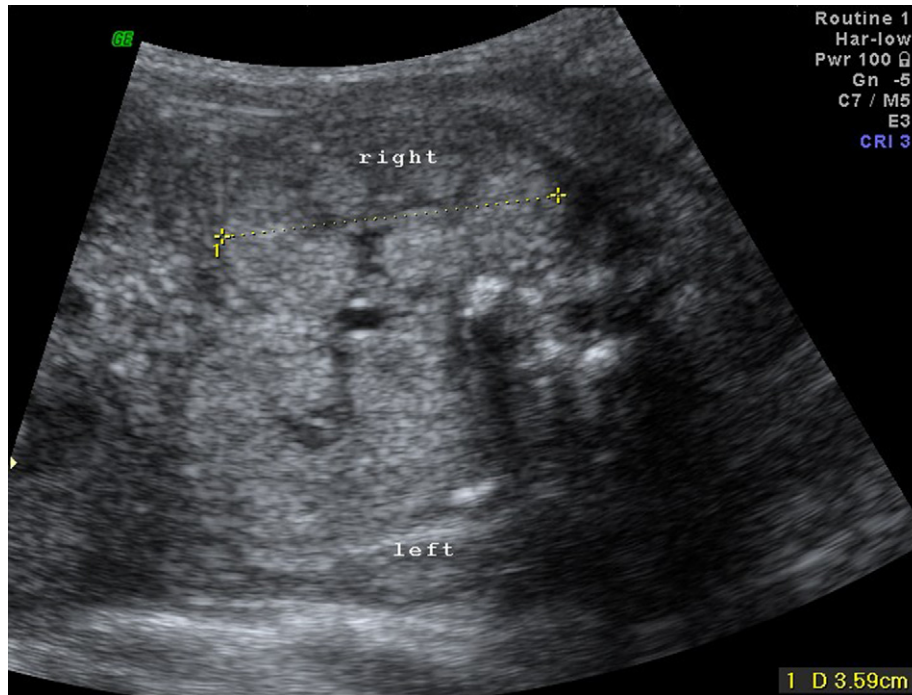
An ultrasound image of bilaterally enlarged echogenic fetal kidneys (case 1).
